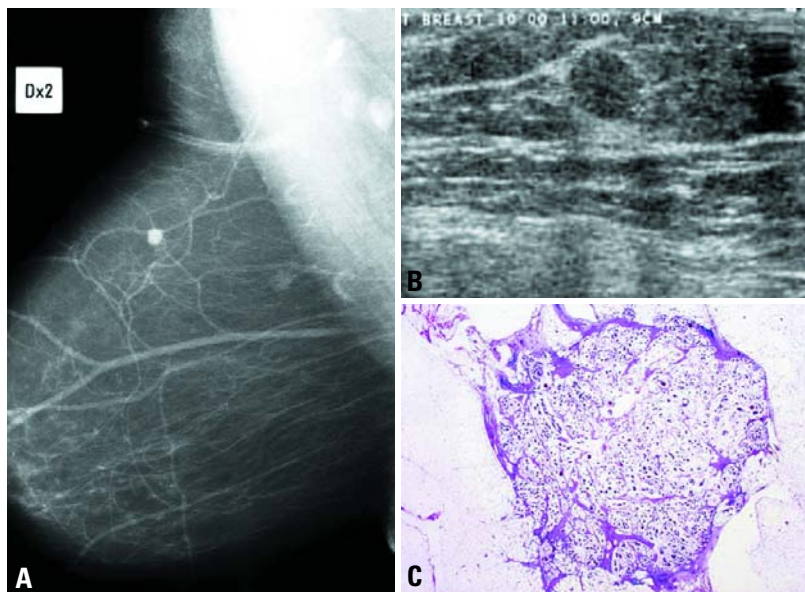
Mucinous carcinoma. A Mammogram showing small rounded density of less than 10 mm diameter in the upper-outer quadrant. B Ultrasound suggests mucinous carcinoma. C Low power view of the mucinous carcinoma.
